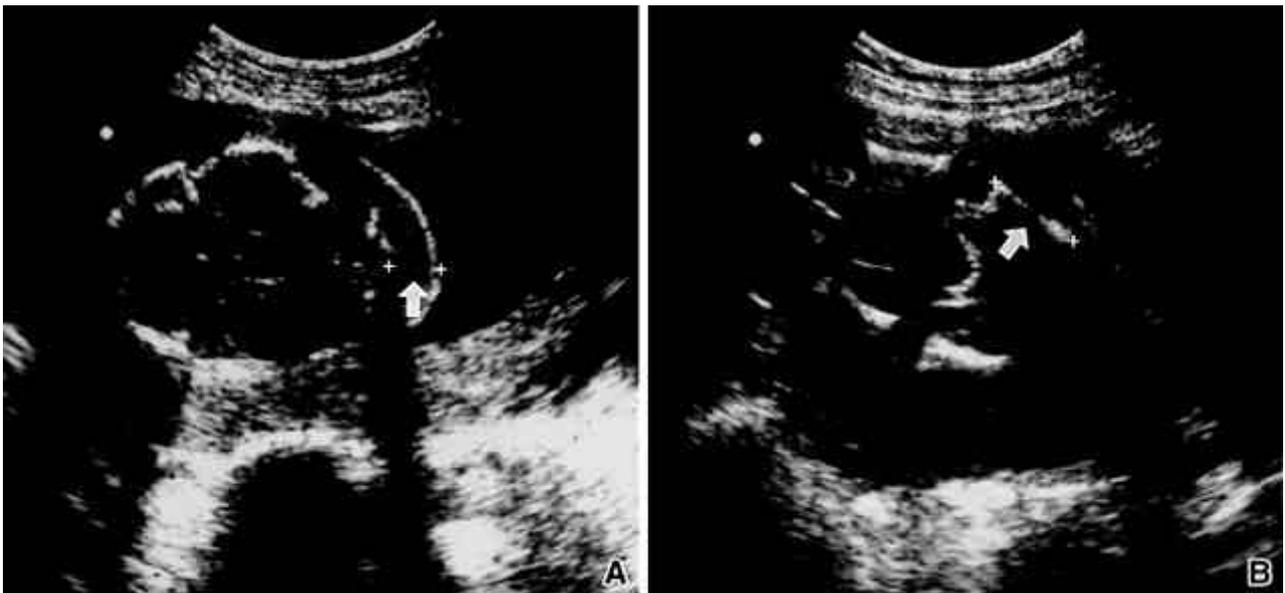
Ultrasonography at 22-week gestation shows nuchal edema (A) and markedly shortened femur (B). (observed femur length/expected femur length :  $2.31 / 3.2 = 0.72$ )
